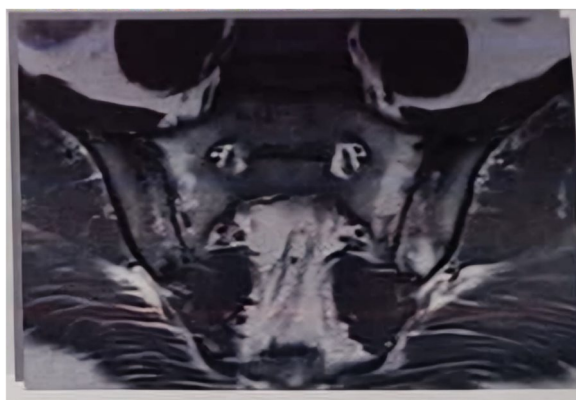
T2 MRI of SIJs (coronal view) of a 34-year-old male AS patient with 3 years of disease duration, positive HLA-B27 showed bilateral active sacroiliitis evident by bone marrow edema (blue arrows) and erosions (yellow arrow) "SPARCC score 19"
